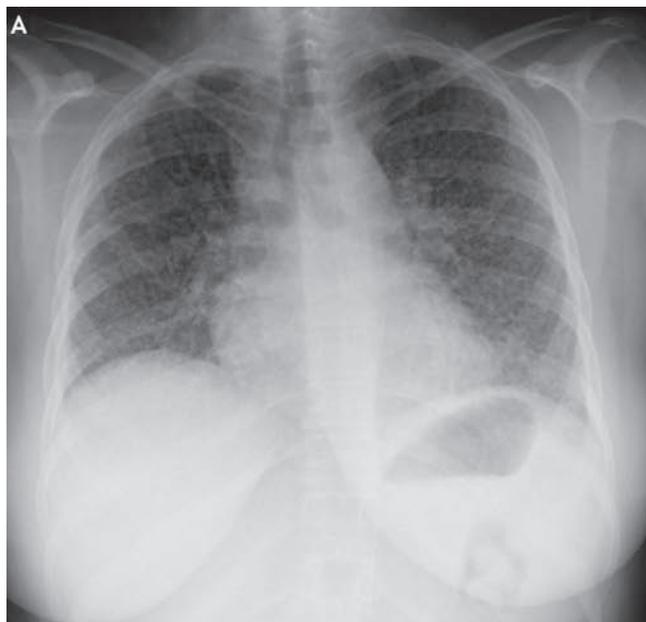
A. Chest radiograph demonstrates diffuse bilateral pulmonary micronodules in a miliary pattern. B. High-resolution computed tomography shows miliary nodules throughout both lung fields.
